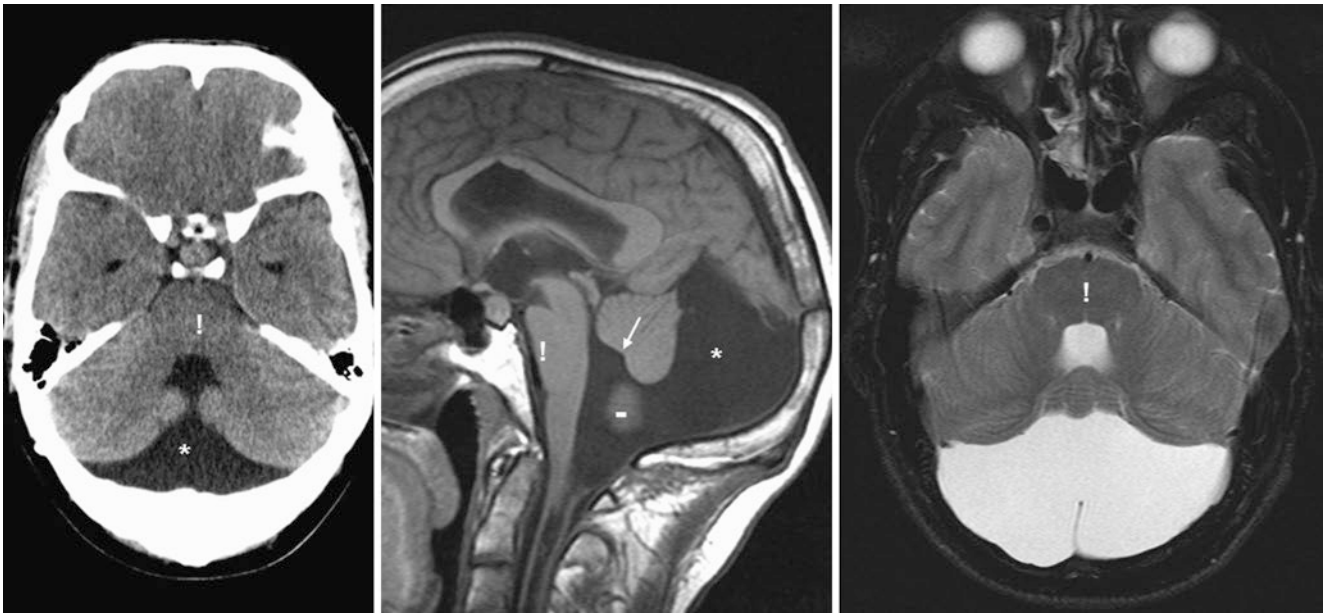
Comparison case of Dandy-Walker syndrome in a chronically shunted patient. In a 31 year old with long-term ventriculostomy shunt catheters to treat hydrocephalus, an MRI demonstrated a mildly enlarged posterior fossa (or fourth ventricular) cyst (*) on axial NECT (left), sagittal T1WI (middle), and on an axial T2WI at a level slightly higher than the CT (right). The posterior angle of the fourth ventricle (arrow) is too obtuse on the sagittal T1WI, indicating moderate CVH. The pons (!) is compressed against the sphenoclivus junction and clivus
